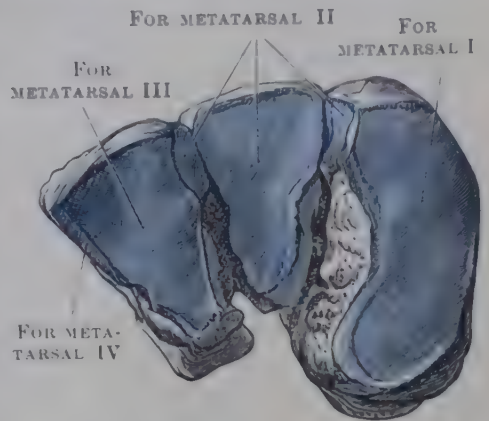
ANTERIOR ASPECT OF CUNEIFORM BONES OF RIGHT FOOT.
